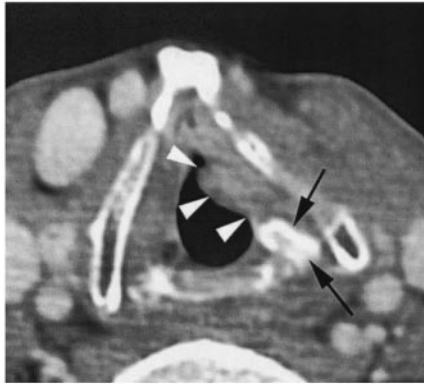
Axial contrast-enhanced CT image of a 67-year-old male patient with a glottic cancer (T2N0). A left-sided glottic soft tissue mass is seen (arrowheads). The tumor abuts the left arytenoid, which shows a clearly increased attenuation (arrows; compare with opposite side). Extended hemilaryngectomy was performed. No postoperative radiation therapy was administered. There is no evidence of disease 2 years after surgery.
